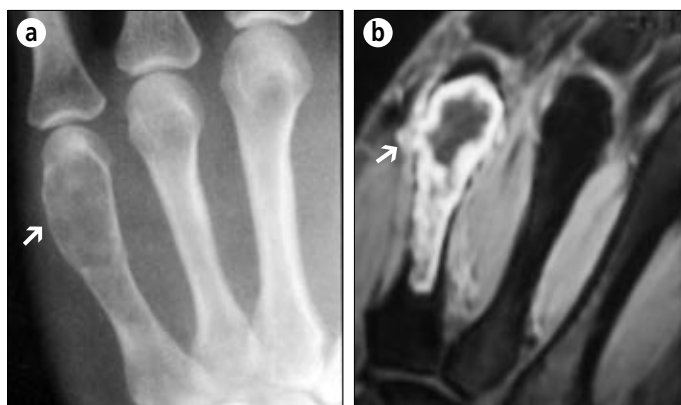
(a) Radiograph of the hand shows an expansile, intramedullary lesion (arrow) in the distal metacarpal that has eroded the endosteal margin of the cortex. (b) Coronal T2-weighted MR image of the hand demonstrates a lobulated, endosteal mass that has eroded and penetrated the endosteal cortex (arrow). (Courtesy of Karl A. Glastad, MD.)
